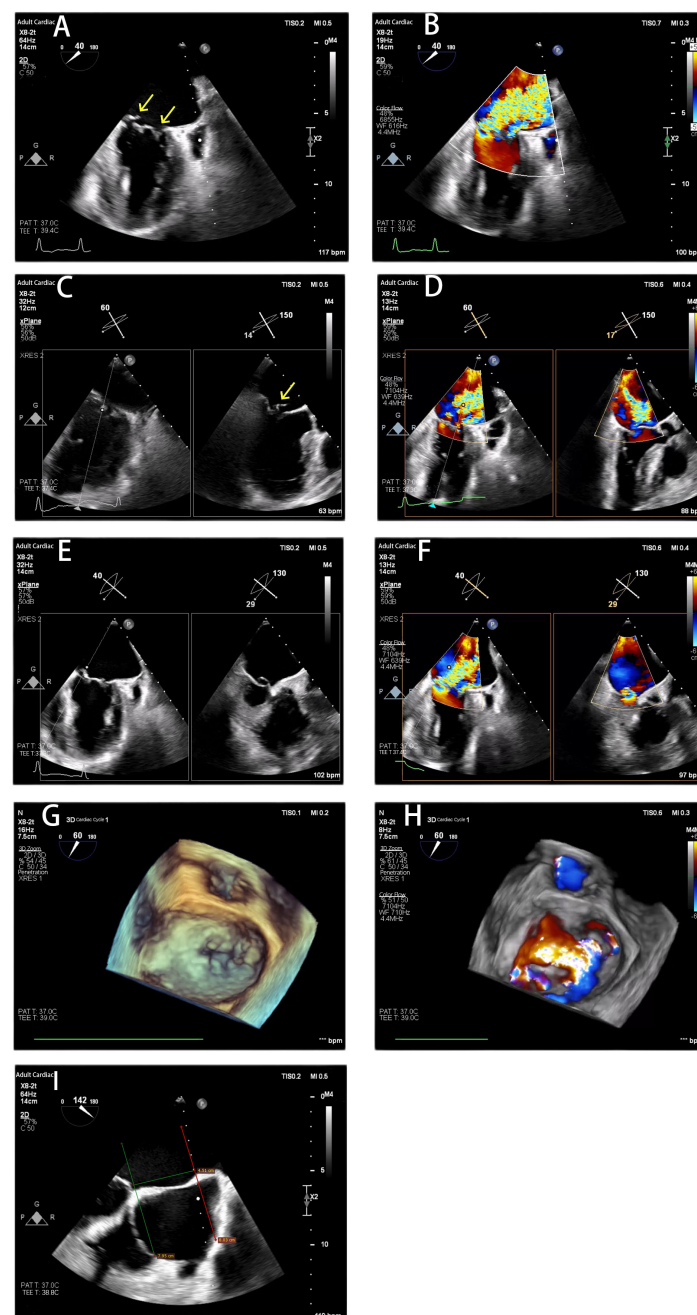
Transesophageal Echocardiography Before the Procedure. (A and B) X-Plane commissural view showed prolapse in zone 1 and zone 3 and severe mitral regurgitation before the procedure; (C and D) X-Plane A1/P1 view showed A1 prolapse and severe mitral regurgitation; (E and F) X-Plane A3/P3 view showed prolapse from P3-C2 and severe mitral regurgitation; (G and H) Three-dimensional TEE shows severe mitral valve regurgitation; (I) The length of the atrial septum was 4.51 cm. The yellow arrow indicated the origin of the Mitral regurgitation. TEE: Transesophageal echocardiography.
